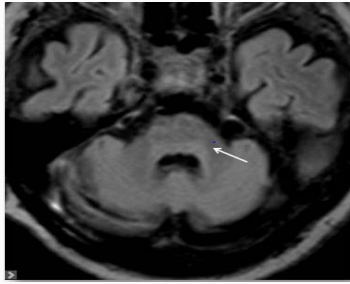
Total regression of the tumor in the pons with residual gliosis and severe atrophy in FLAIR images (white arrow).
